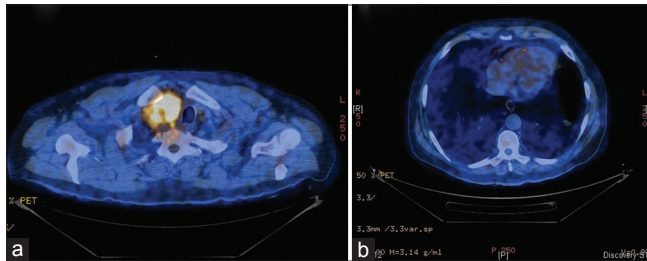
(a) Positron emission tomography (PET)-computed tomography scan showing an ill-defined heterogeneous mass with a large necrotic component and increased metabolic activity in the right lobe of thyroid standardized uptake value (SUV - 7.2) which was causing mass effect over right neck great vessels and trachea. (b) PET avidity in the nodule in left lower lobe lung (SUV - 1.7)
